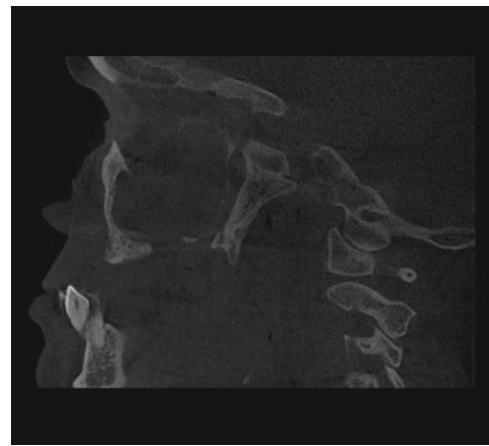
Sagittal section of CBCT (left side).
